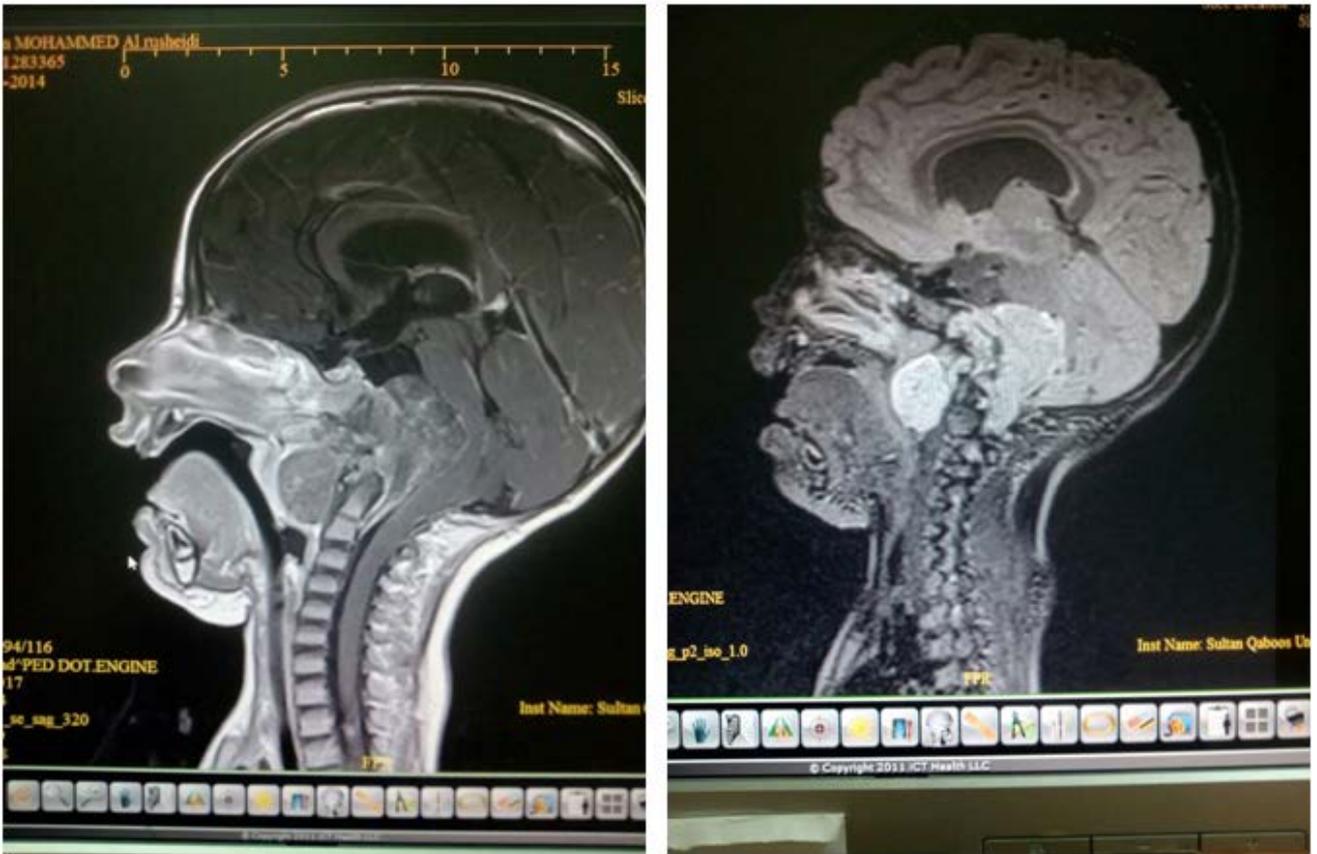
Pre op MRI pictures of the lesion
